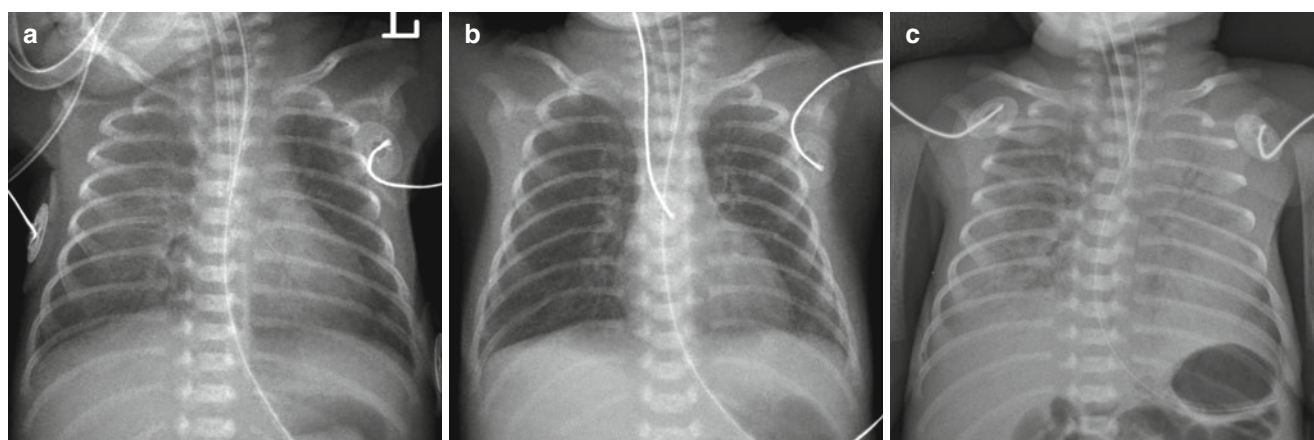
Sudden onset of a *white-out* has several possible explanations. Pulmonary hemorrhage in a 26-week-gestational-age neonate following surfactant therapy. (a) Frontal chest radiograph obtained after one dose of surfactant shows asymmetric clearing of opacities with the left lung improved more than the right. (b) Radiograph, taken after
